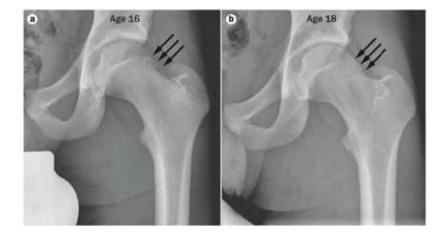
Development of cam morphology. The left radiograph shows the hip of a 16-year-old asymptomatic male elite soccer player and an extension of the growth plate into the femoral neck is present (arrows). The right radiograph is a follow-up radiograph of the same individual two years later, where cam morphology is present. Note that, at age 16, most of the physis is closed, except for the anterolateral part where the cam is seen at a later stage. Reprinted with the permission of Springer Nature, Nature Reviews Rheumatology, Cam impingement of the hip—a risk factor for hip osteoarthritis, Agricola et al., 2013.
